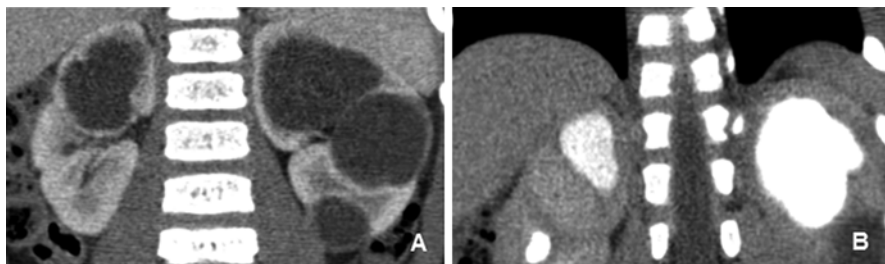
CT scan of calyceal diverticulum with delayed images. (a) During the nephrogenic phase, the fluid filled structures within the kidneys appear as large simple cysts. (b) During the delayed phase, contrast is seen filtering into these fluid-filled structures, indicating calyceal diverticula
